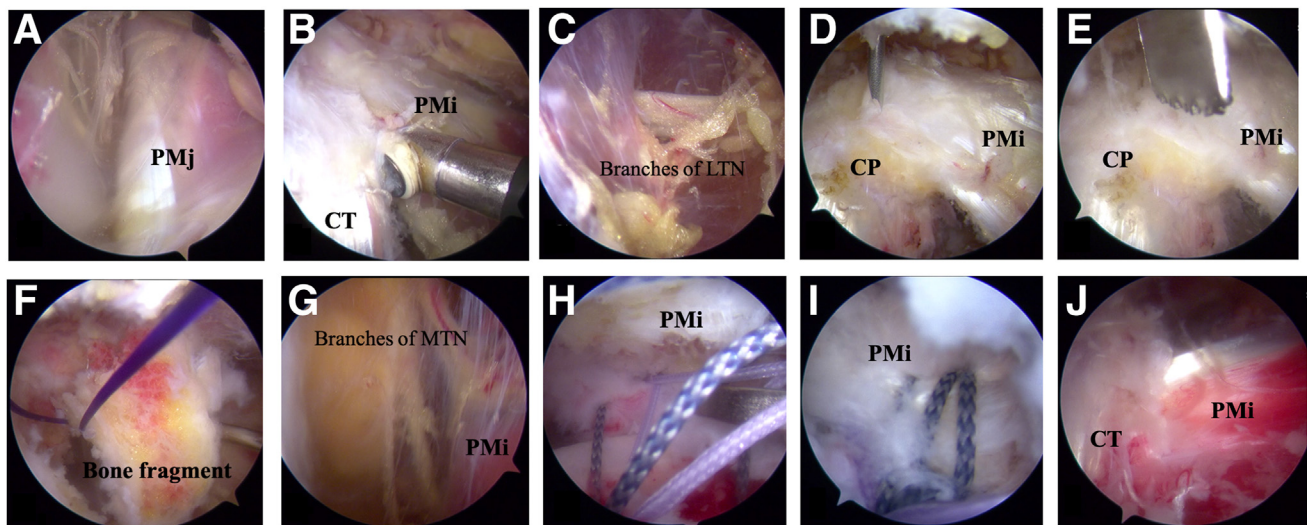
Arthroscopic procedure. (A) The lateral border of conjoint tendon was exposed down to the upper border of the PMj tendon. (B) The upper and lower borders of the PMi tendon and muscle were released. (C) Medial release of the PMi was performed to the branches of the lateral thoracic nerve between the PMi and PMj muscles. (D) The needle was used to create G portal. (E) The electric saw was used to perform osteotomy on the cortex 3 to 4 mm lateral to the medial margin on the coracoid process where the PMi was inserted. (F) PDSII sutures were passed around the tendon-bone junction as traction sutures to pass the PMi under the coracoid. (G) The posterior of the PMi was released, and care should be taken to avoid to injury the plexus and nerve branches of medial thoracic nerve. (H) Horizontal mattress sutures through the inferior and superior aspects of the bone-tendon junction. (I) Lateral row fixation. (J) PMi tendon behind the conjoint tendon after fixation was shown. CT, conjoint tendon; LTN, lateral thoracic nerve; CP, coracoid process; MTN, medial thoracic nerve.
